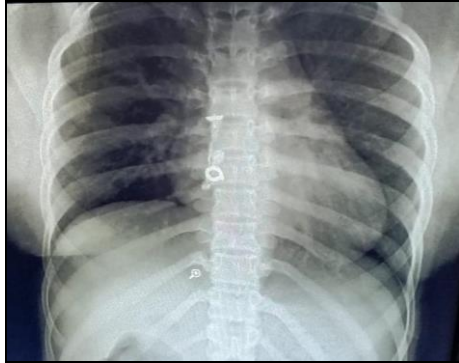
X-ray sinogram – anterior view
